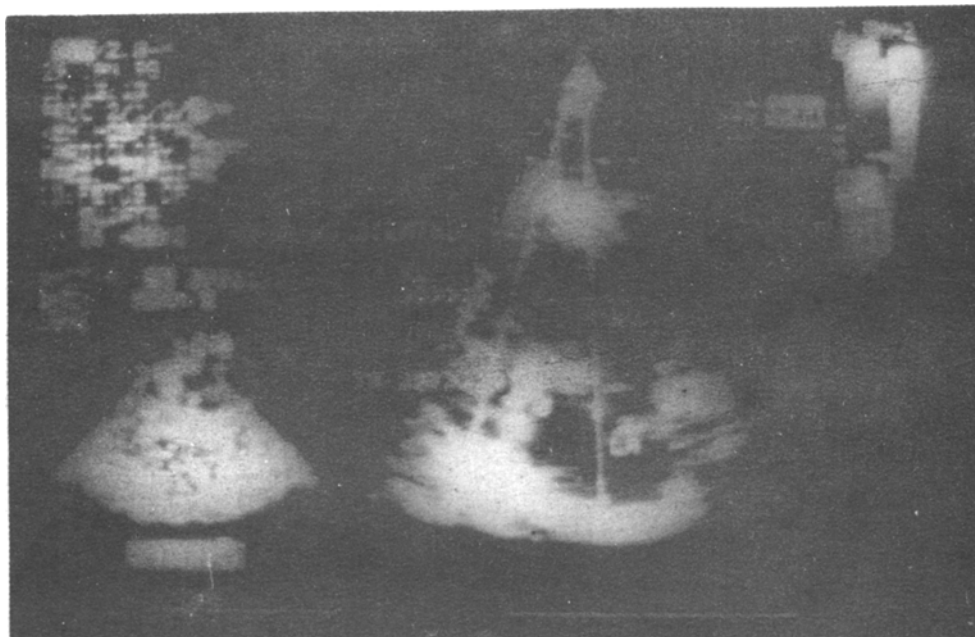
Four chamber view of fetal echocardiography showing dilated right atrium [RA], right ventricle [RV] and tricuspid regurgitation [TR jet].
